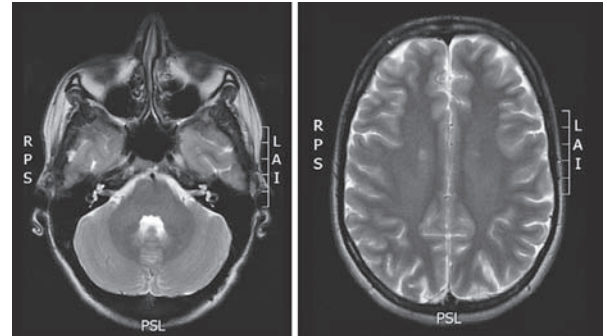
Brain magnetic resonance imaging (MRI), T2 sequences of the patient with multiple sclerosis who presented with paraparesis. Left figure shows normal MRI at the level of the brainstem. Right figure shows multiple periventricular lesions.
